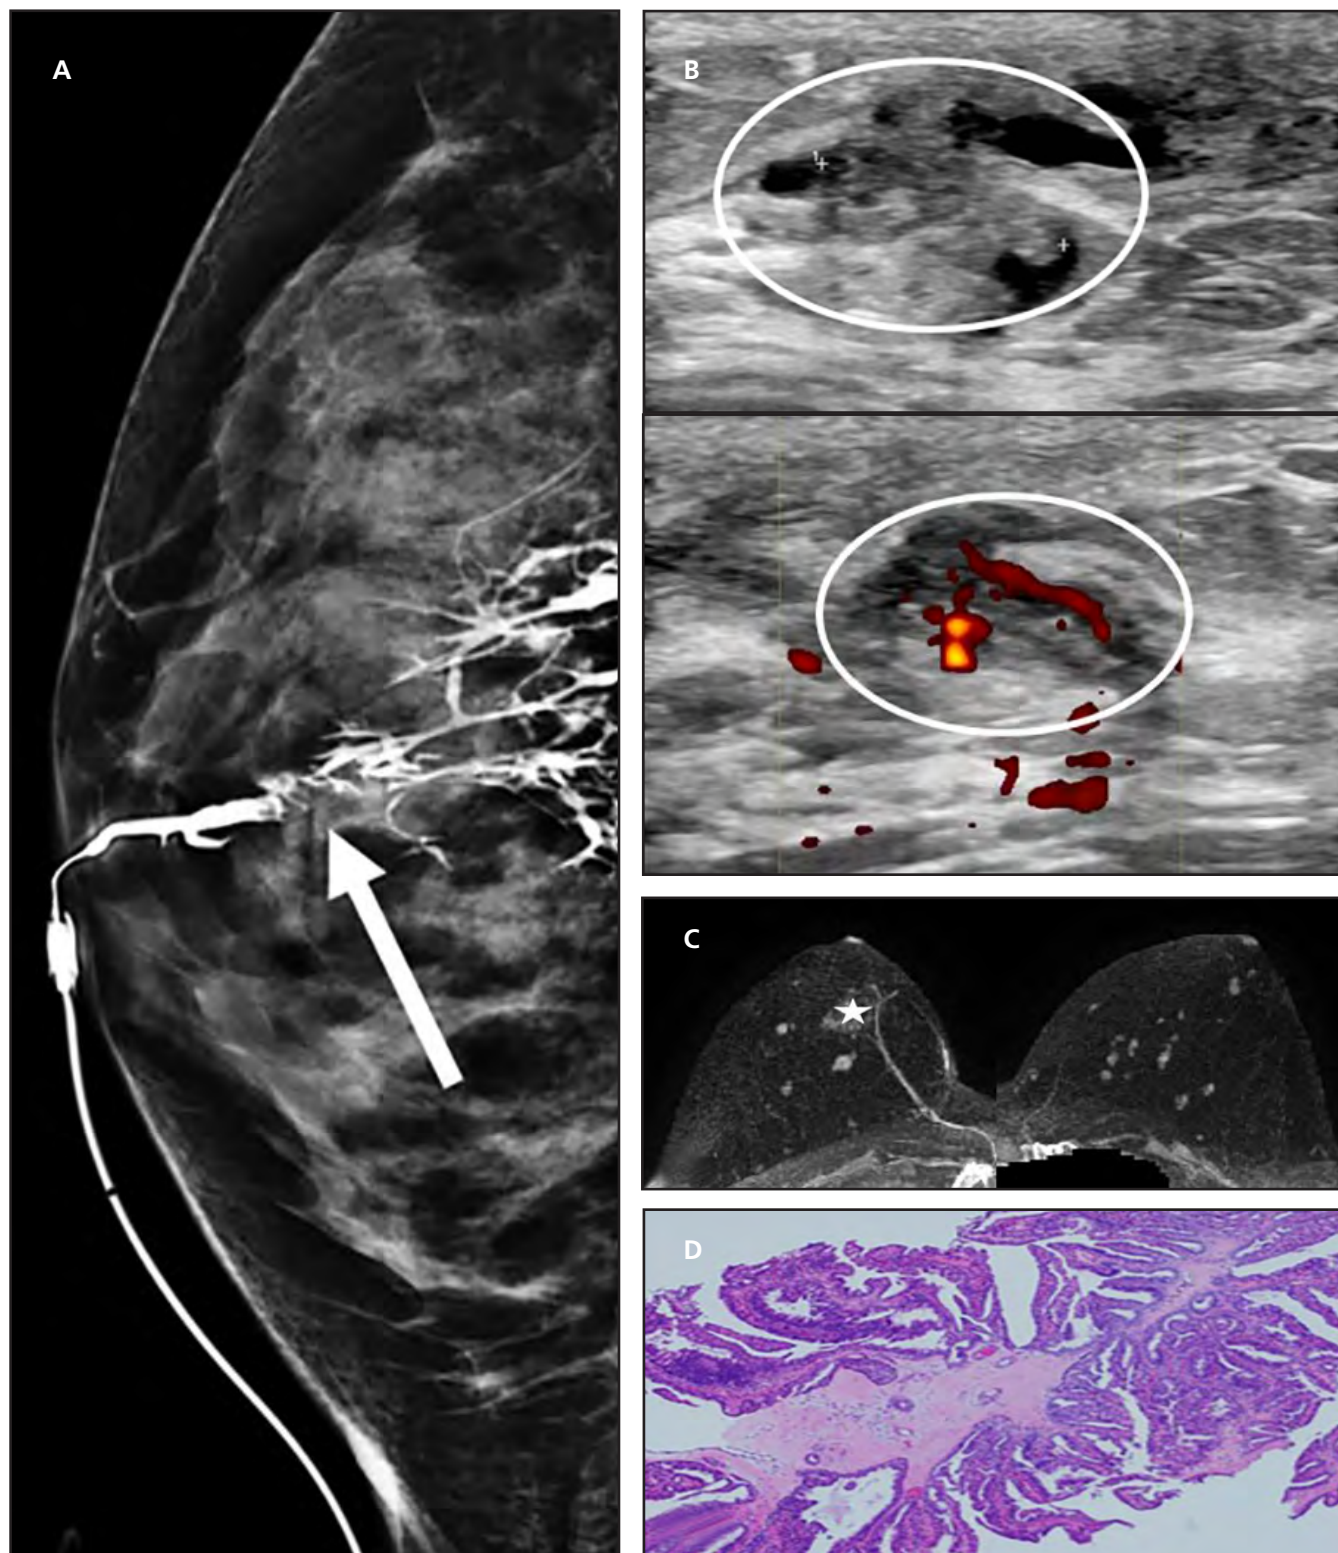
Papilloma presenting as nipple discharge. A 23-year-old woman with spontaneous bloody nipple discharge. Ductography demonstrates an intraluminal filling defect in the subareolar right breast (arrow) (A). Transverse and sagittal ultrasound images demonstrate a corresponding intraductal mass with internal vascularity measuring 11 mm (B). Vacuum-assisted biopsy was performed demonstrating intraductal papilloma without atypia. Nipple discharge stopped after the biopsy. No surgical excision was performed. Subsequent MRI was performed demonstrating multiple bilateral masses as demonstrated on the MRI maximum projection images (C). Postbiopsy change is denoted by the white star. Pathology slide demonstrates a classic appearance of papillae with fibrovascular core (D).
